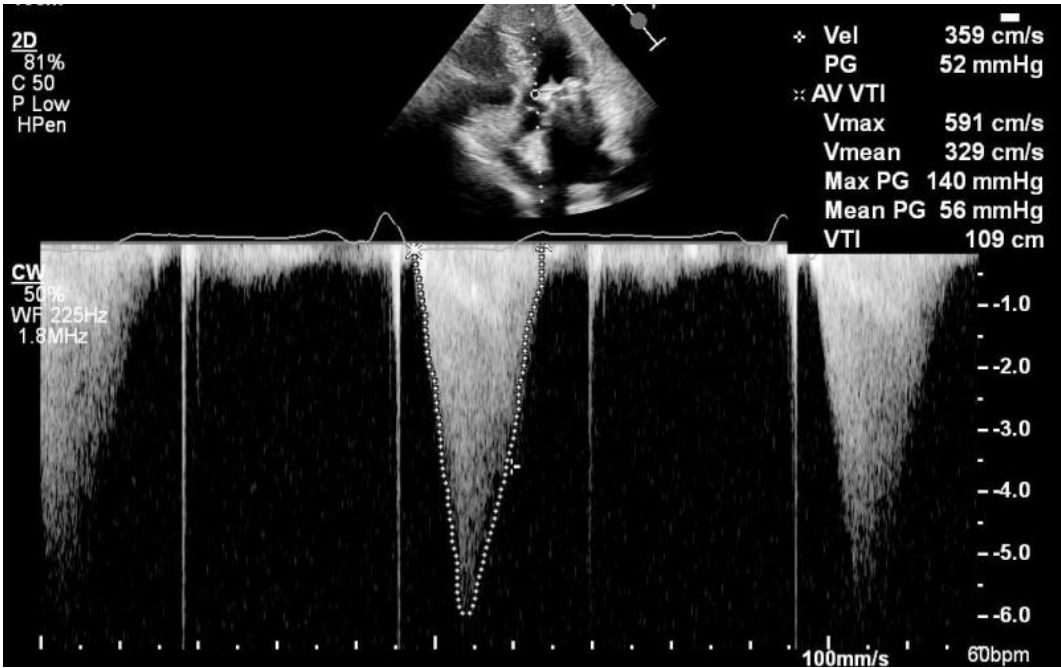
Continuous flow Doppler: Peak and mean gradients at the LVOT level
